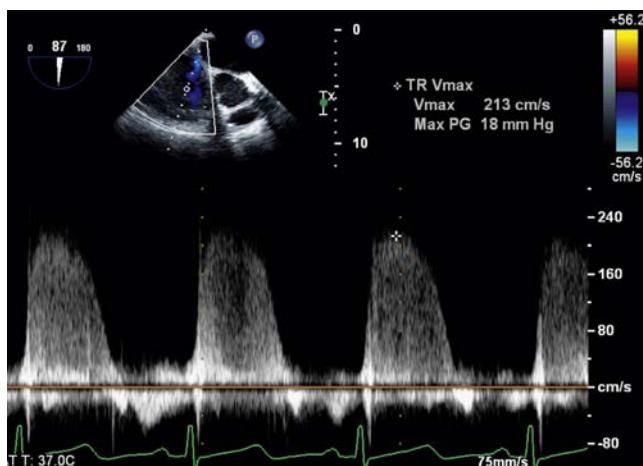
A midesophageal modified bicaval view aligns the Doppler cursor with the tricuspid regurgitant jet. Continuous wave Doppler measures the peak systolic velocity of the tricuspid regurgitation (V_{TR}). V_{TR} reflects difference between the right ventricular systolic pressure (RVSP) and right atrial pressure (RAP), so $RVSP = 4 V_{TR}^2 + RAP$. In the absence of right ventricular outflow tract obstruction or pulmonary stenosis, RVSP and pulmonary artery systolic pressure (PASP) are essentially equal. In this example, the estimated PASP = 18 mm Hg + RAP.
